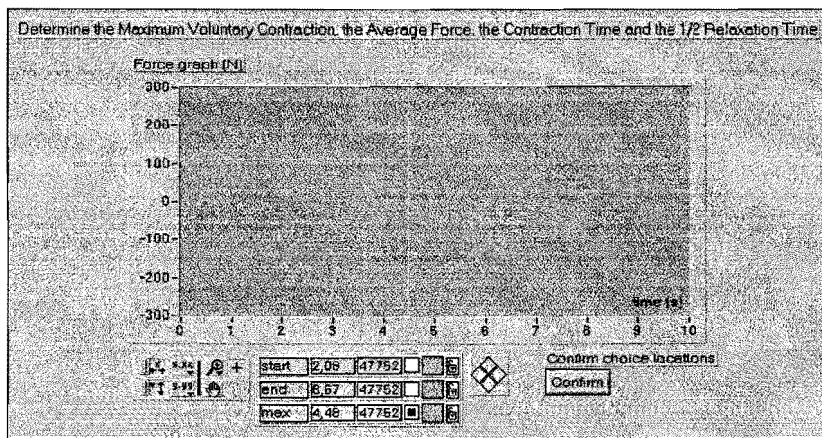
The "Determine the Peak Force, Average Force, CT and 1/2RT" menu.
